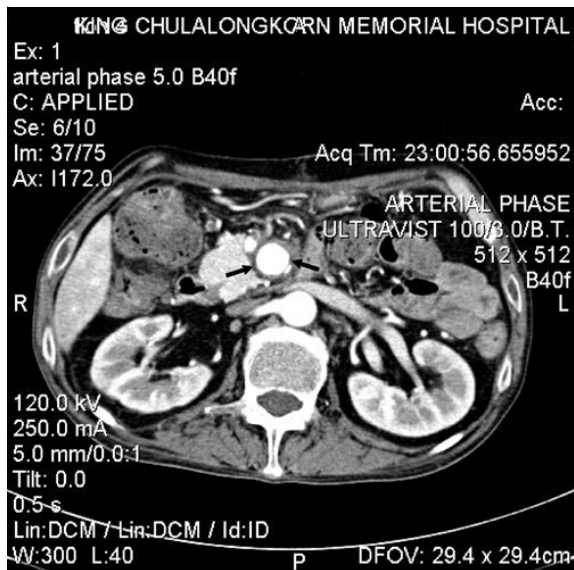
Preoperative computed tomography of the abdomen showing a 2.2-cm diameter aneurysm of the proximal SMA (arrows)
